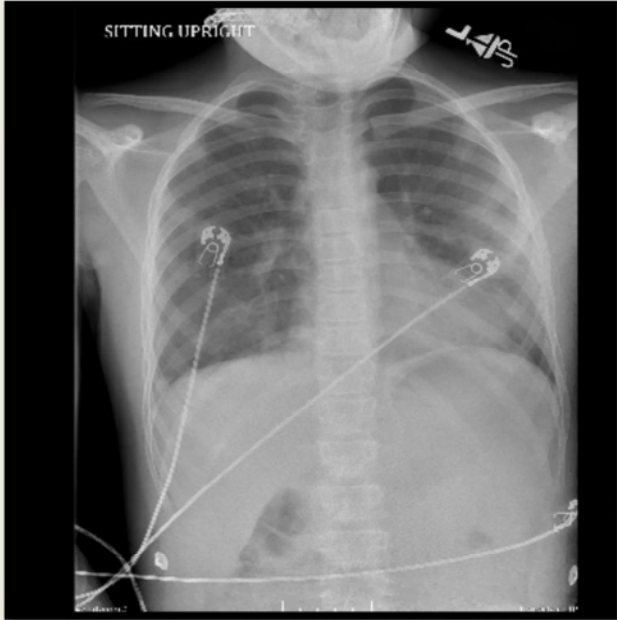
AP chest X-ray showing mild bilateral hazy opacity
